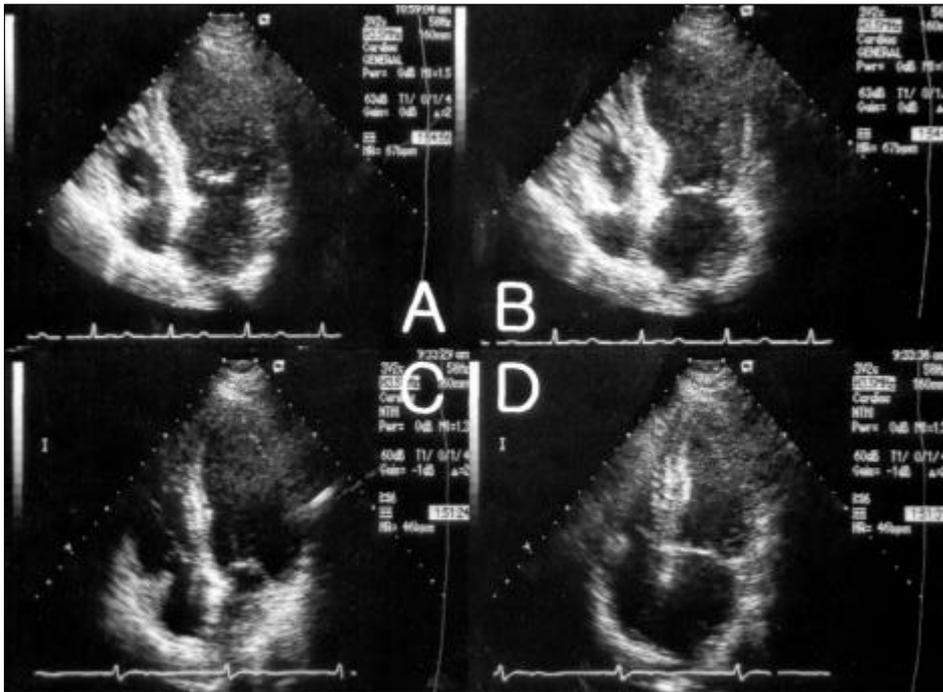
Echocardiograms during diastole (A) and systole (B) on arrival. They show impaired contractility sparing the basal segments. Echocardiograms during diastole (C) and systole (D) after 4 months, which show normal contractility with no regional wall motion abnormality.
